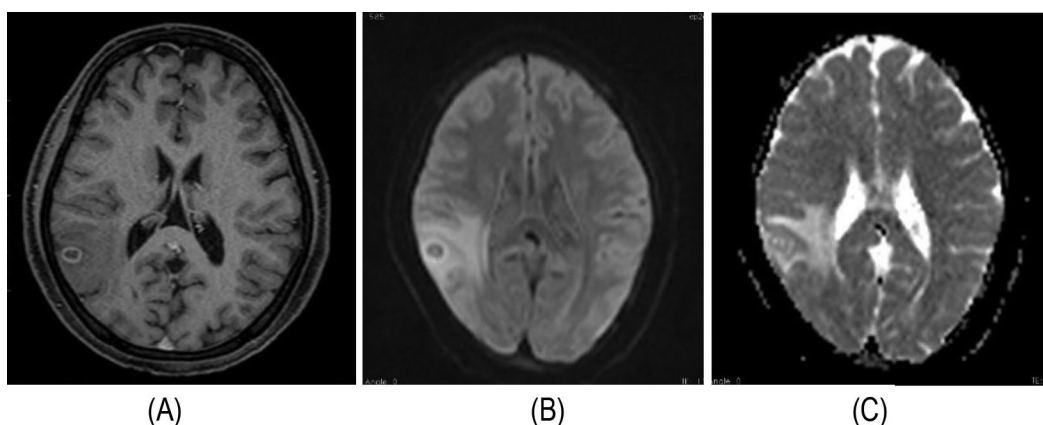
Axial post contrast T1W image of neurocysticercosis showing peripherally enhancing nodular lesion in right parietal region (A), on DWI (B) and on ADC (C).
